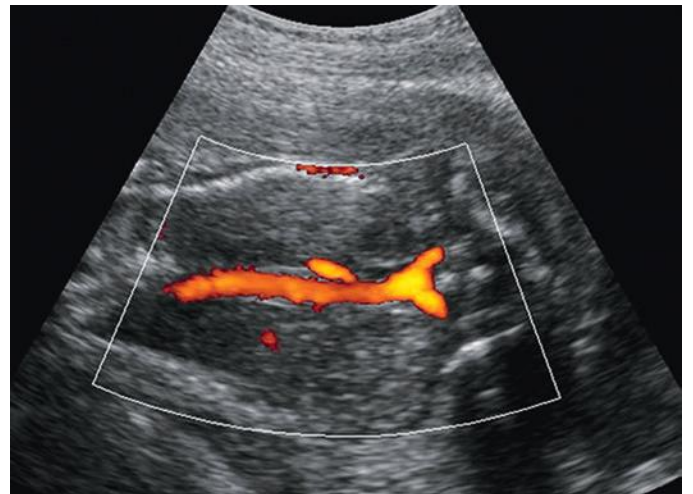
Bilateral renal agenesis. Absence of the renal arteries as demonstrated by color Doppler imaging.
